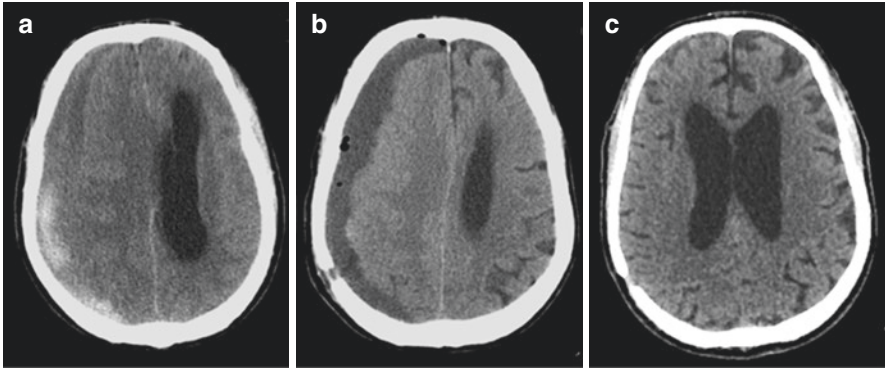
(a) Initial CT scan demonstrating large right frontoparietal CSDH. (b) Three-week follow-up CT scan demonstrating CSDH recurrence. (c) Four-month follow-up CT scan demonstrating total disappearance of the right hematoma
